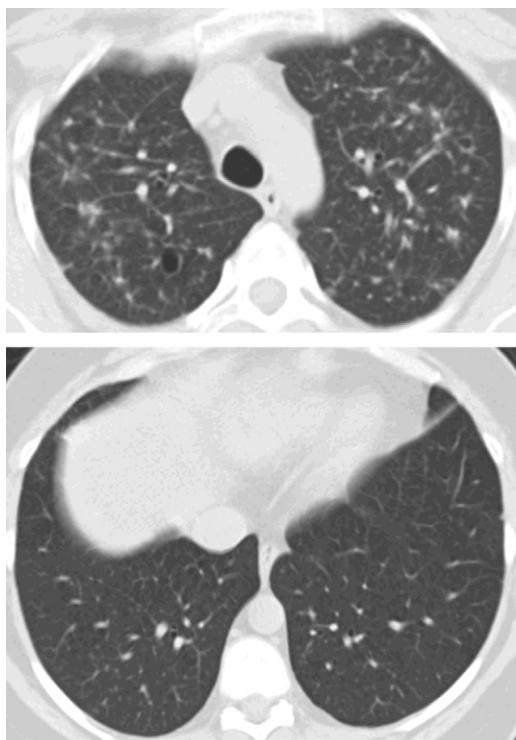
PLCH. HRCT of the chest demonstrating a combination of nodular and cystic lesions in the upper lung fields and relative sparing of the lung bases in a smoker with PLCH.
